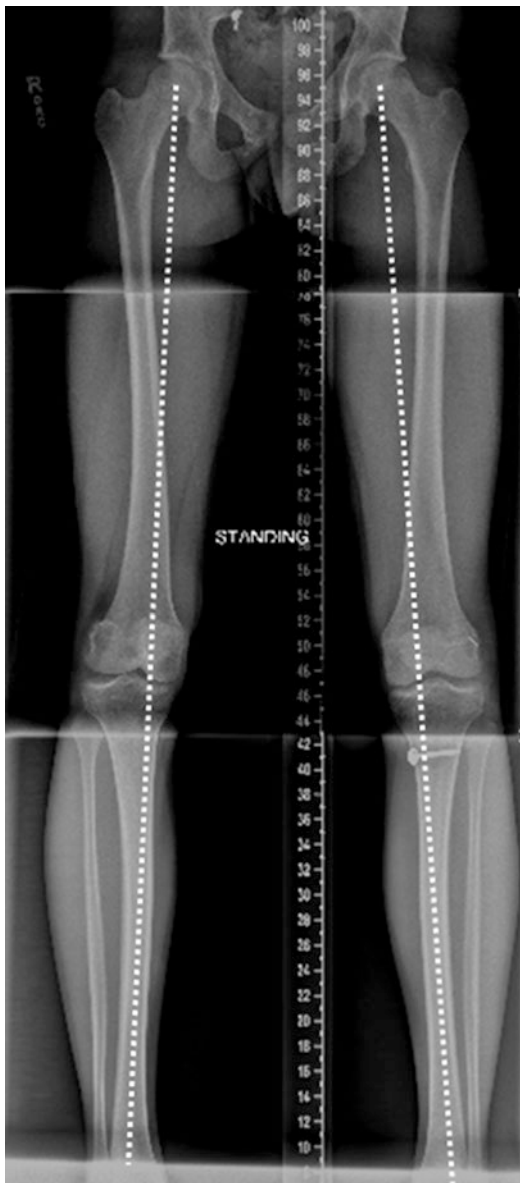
Full length X-ray of a patient who underwent right sided ACL reconstruction using extraphyseal ITB technique at age 10 years. Two years later, he sustained left sided ACL tear and underwent all-epiphyseal ACL reconstruction. At skeletal maturity, there is no limb length discrepancy or deformity and both knees had excellent results
